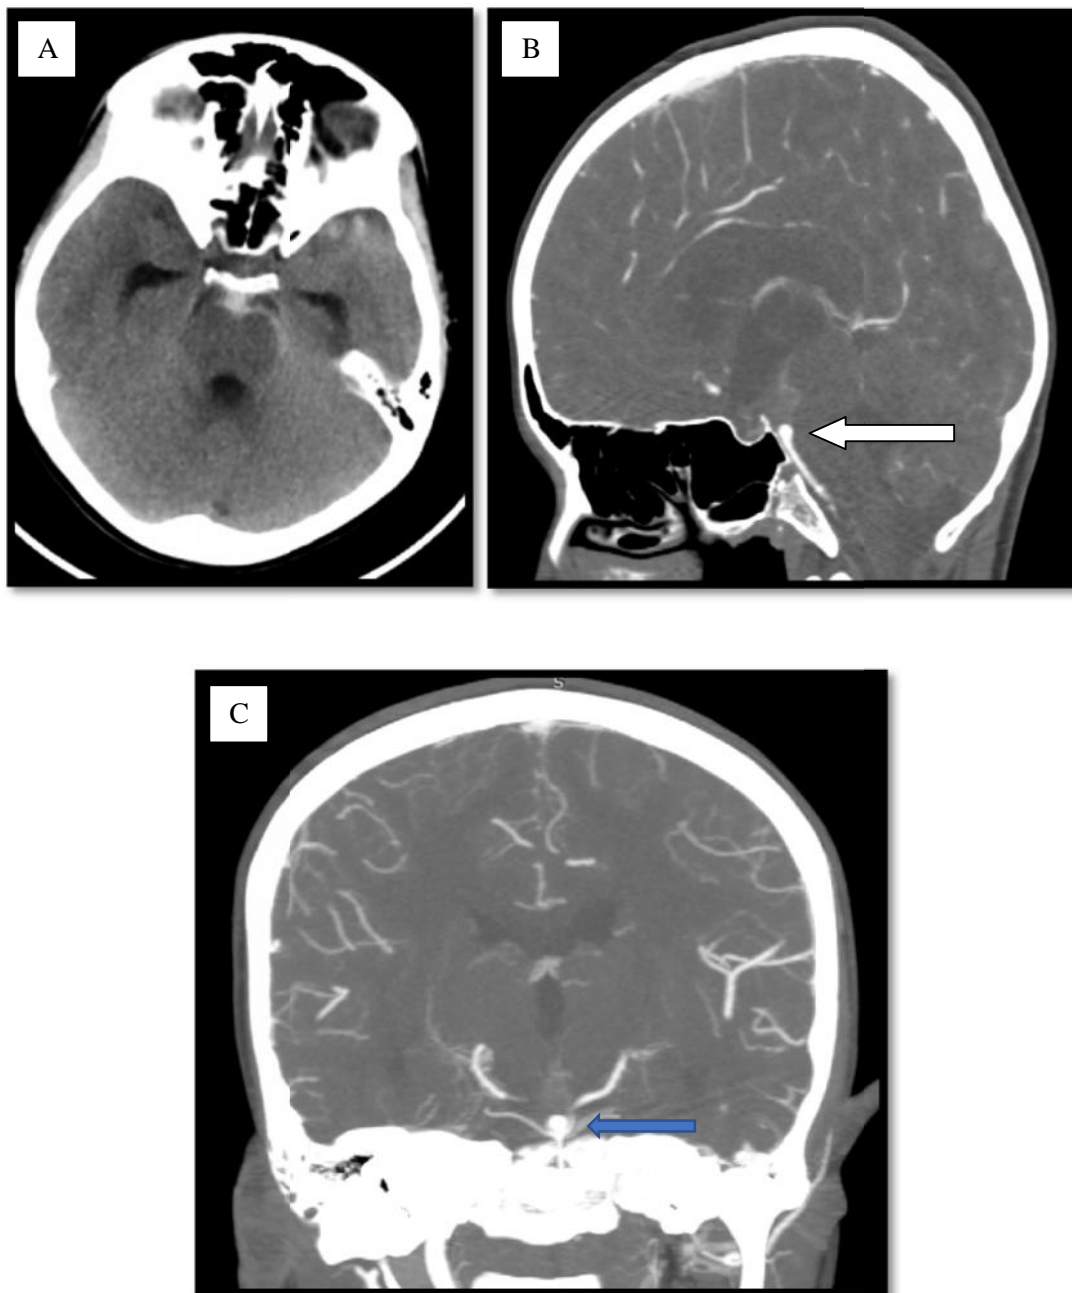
41-year-old male with basilar tip aneurysm (A) Axial precontract CT showing subarachnoid haemorrhage (B) sagittal arterial phase (C) MIP showing saccular aneurysm at the top of the basilar artery
